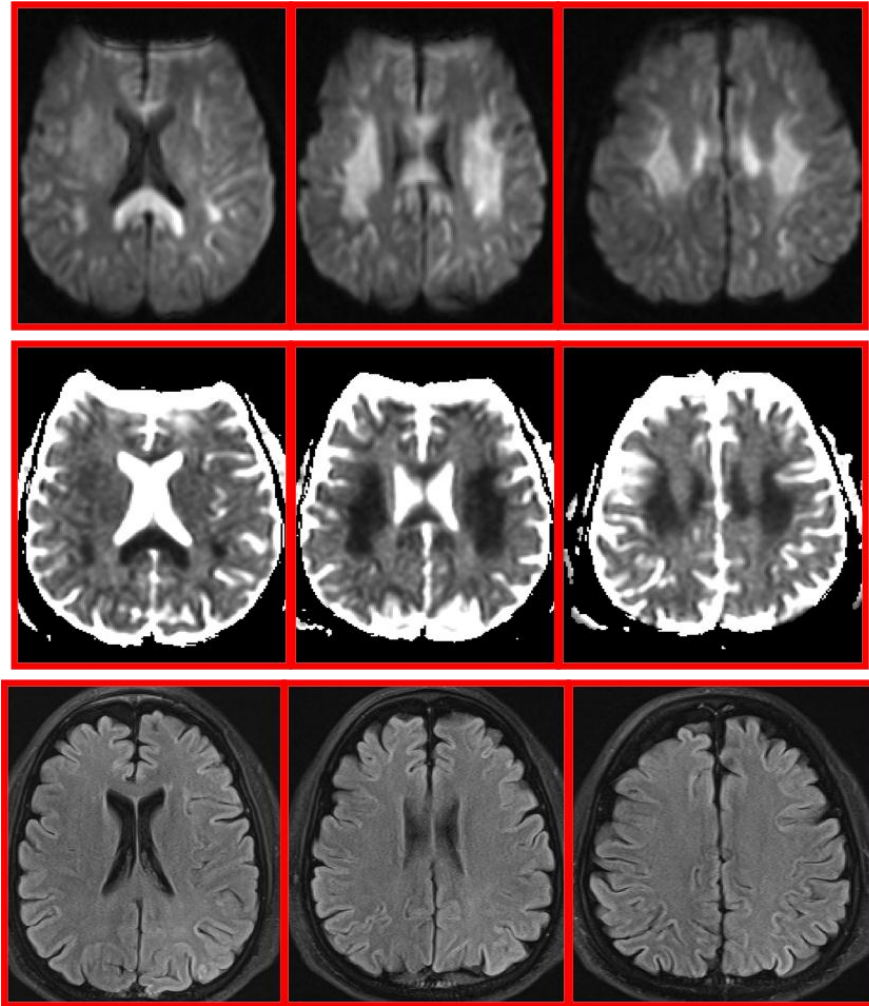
Top row: axial diffusion-weight imaging (DWI) demonstrating bilateral restricted diffusion in periventricular white matter and splenium of corpus callosum. Mid row: axial apparent diffusion coefficient (ADC) demonstrating hypointense signal correlating with DWI restriction. Bottom row: axial, fluid attenuated inversion recovery (FLAIR) images that do not any significant abnormality.
